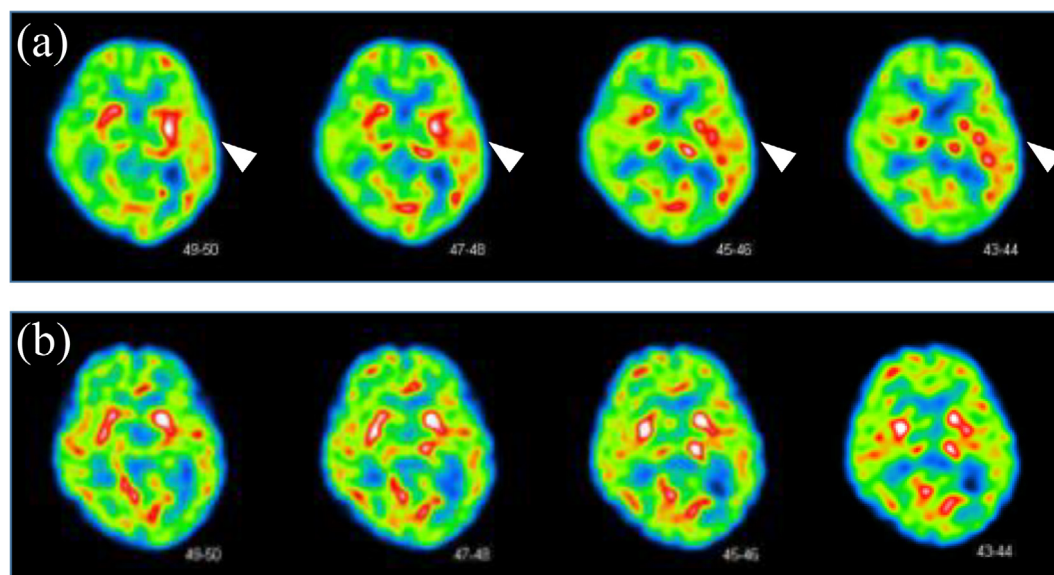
(a) ^{99m}Tc -ECD brain SPECT on the 14th day following the initial convulsions showed hyperperfusion in the left cortical area and basal ganglia (arrow head). (b) Repeated ^{99m}Tc -ECD brain SPECT performed after ACTH therapy on the 35th day showed near complete normalization.
